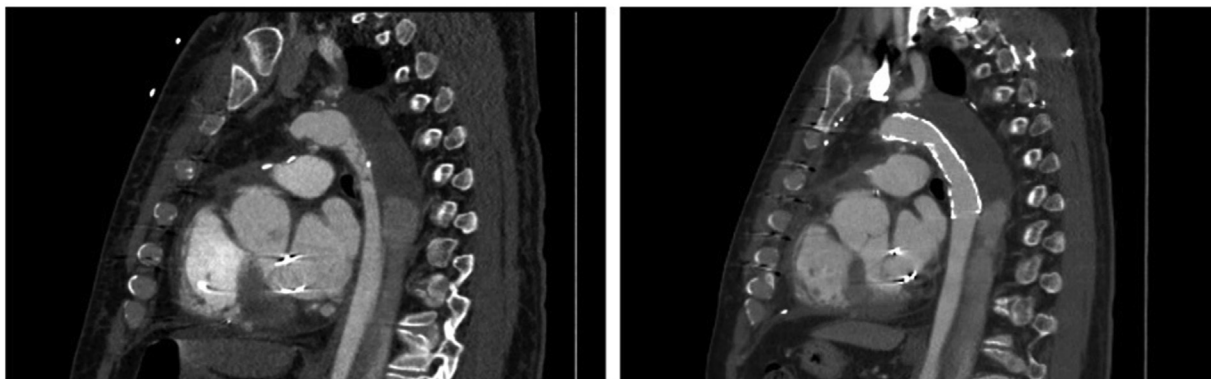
Comparison of sagittal computed tomography angiography (CTA) images before and after thoracic endovascular aneurysm repair.
